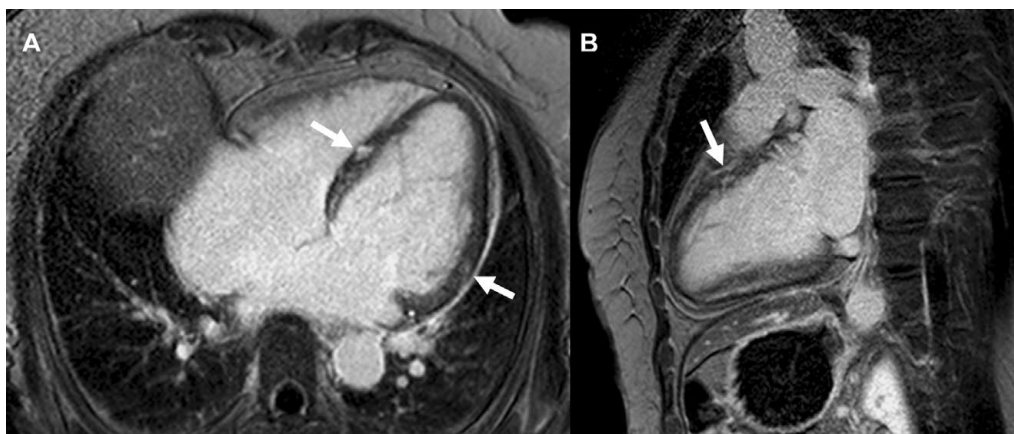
A 59-year-old woman who presented with dyspnea (NYHA III). Initial echocardiography shows LVEF 24% (LVEDD/LVESD 62/54mm). CMR revealed FPE in the septum and LV free wall (A, B). After 2 years of treatment, her symptoms were much improved and follow-up echocardiography shows improved LV systolic function (LVEF 54%, LVEDD/LVESD 53/38mm). (White arrow indicates DE in septum and LV free wall.) FPE, focal patchy enhancement. Other abbreviations see in Figure 1.
